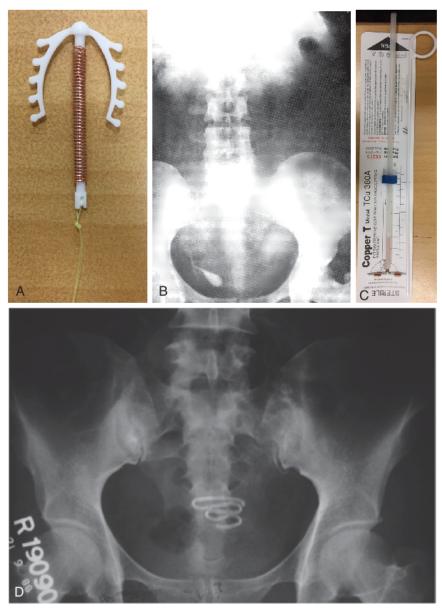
(A) Multiload Copper-T 375. (B) Displaced Copper-T with calcium deposition at tip of T. (C) Copper-T 380A. (D) Pelvic radiograph showing Lipple's loop in the pelvic cavity. (Courtesy (B): Dr K.K. Saxena, New Delhi.)
